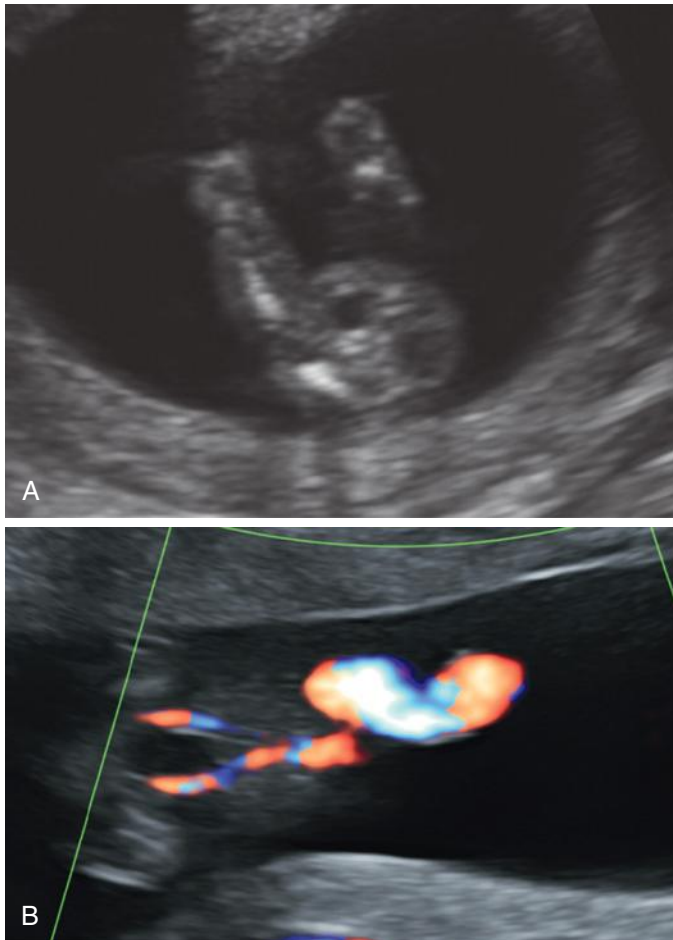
Fetal bladder. A, Bladder is easily demonstrated with gray-scale imaging in this 12-week fetus. B, Color Doppler demonstrates umbilical arteries bifurcating around the fetal bladder.
